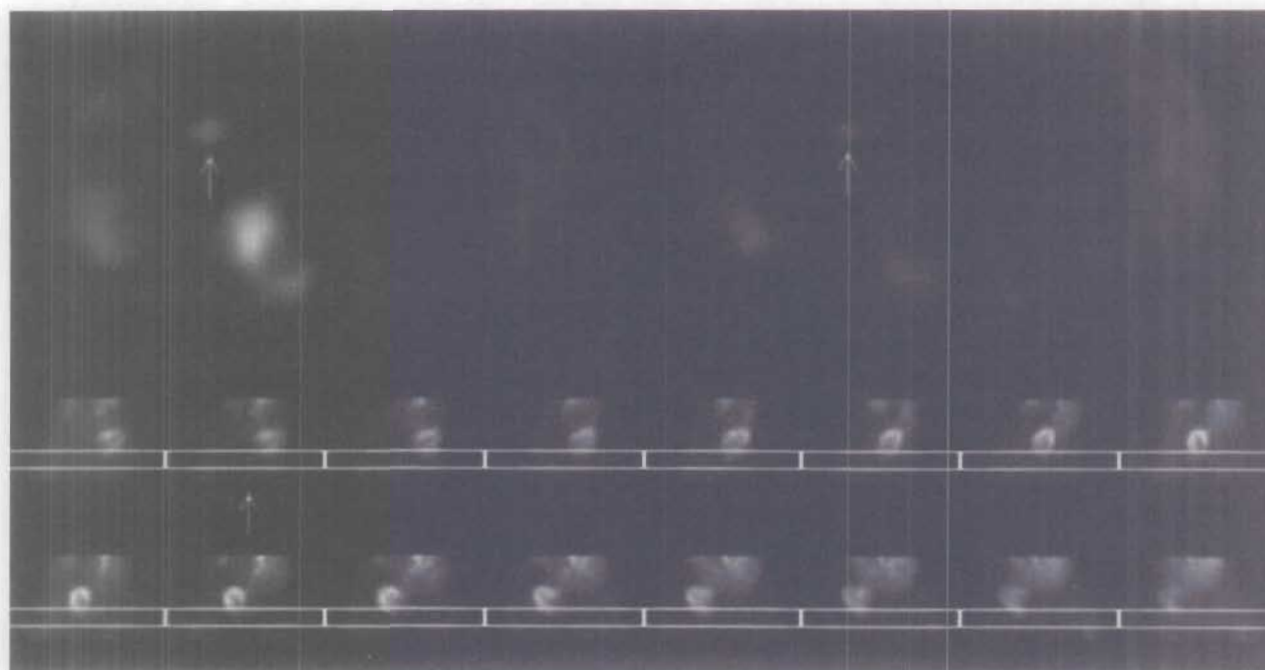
Planar projection images (*top*) and transaxial slices (*bottom*) are from a man with a focal region of intrapulmonary TET uptake in his left lung (*arrowhead*). The patient had no evidence of lung cancer on follow-up for 3 years. This case and 8 other similar appearing lesions on TET (4 included in this study and 4 later cases) without evidence of lung cancer or nodules on clinical follow-up, chest radiography, or computed tomography scanning of the thorax all underwent injection by the same technologist. After the technologist's technique was observed, it was concluded that this might be related to not clearing (flushing) the back-flow of blood occurring during exercise stress from the indwelling catheter before administration of TET. This suggests that the small clinically insignificant thrombi that are routinely flushed into the intravenous line can be "tagged" with TET. No further incidence of this phenomenon occurred after flushing the catheter before tracer injection became the standard technique for all technologists.
